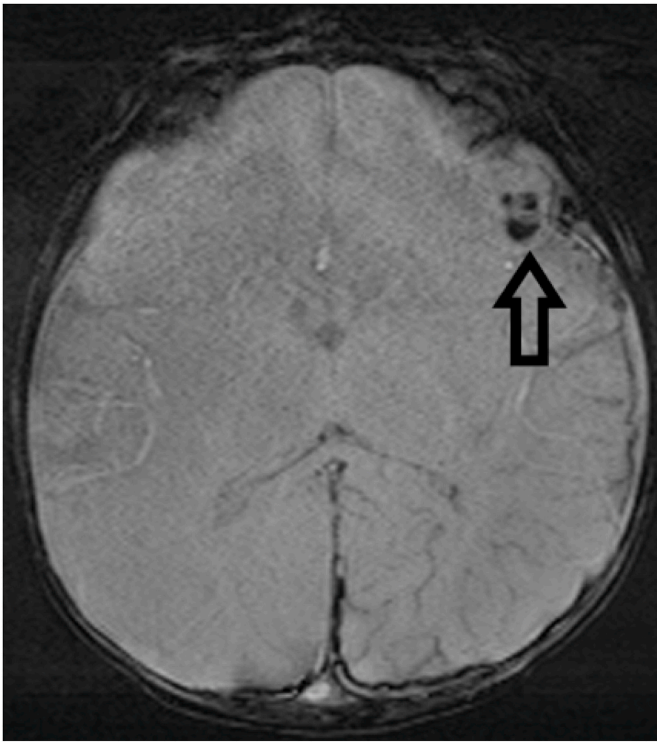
Axial view of susceptibility weighted imaging sequence of brain MRI. The arrow demonstrates the left fronto-temporal hemorrhagic contusion.
